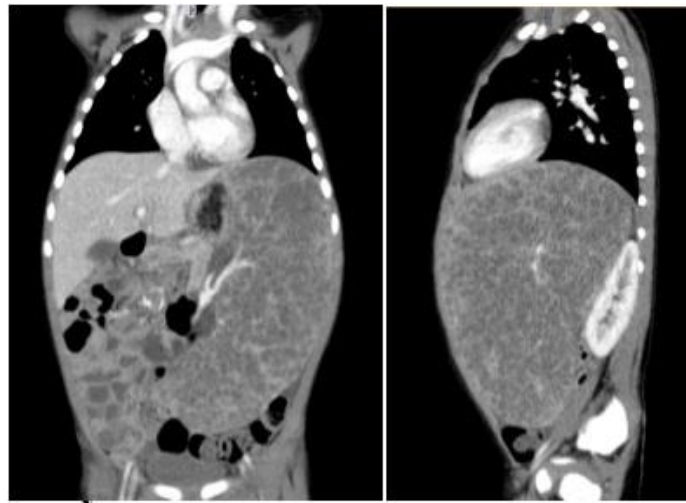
Coronal and sagittal thoraco-abdominal CT scan showing huge heterogeneous spleen extending to the pelvis, along with increased pancreas and posterior mediastinal masses
